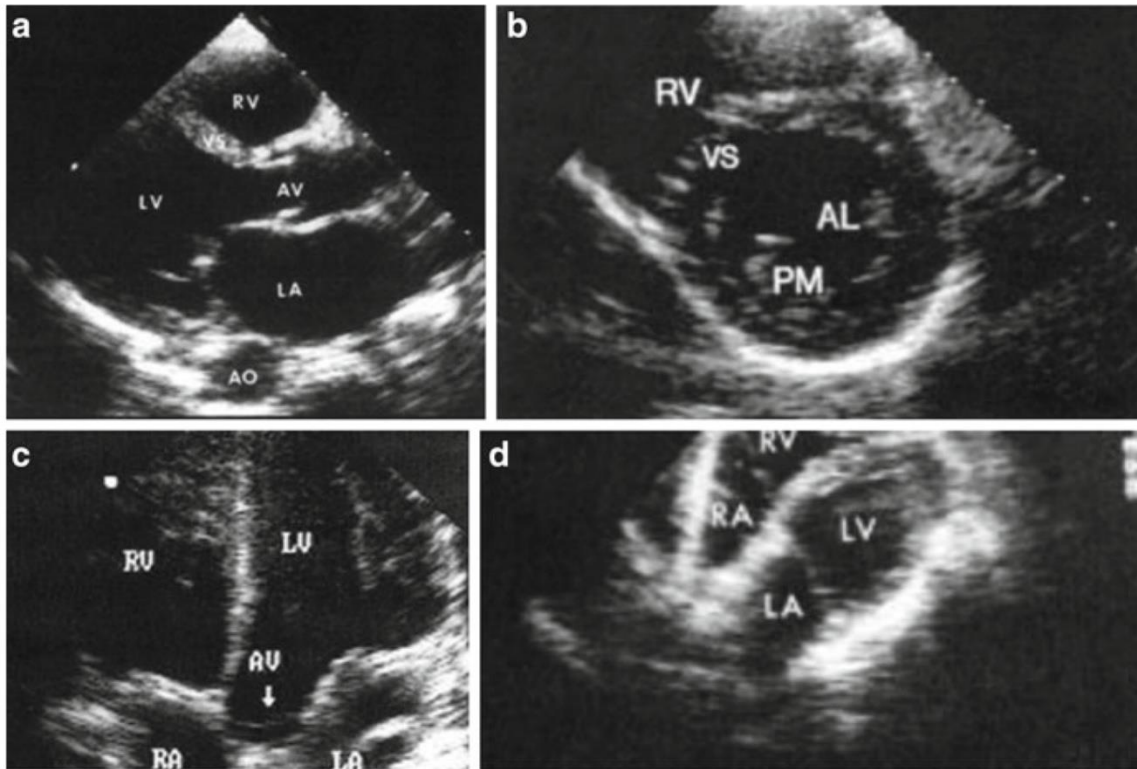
Four basic echocardiographic views:
